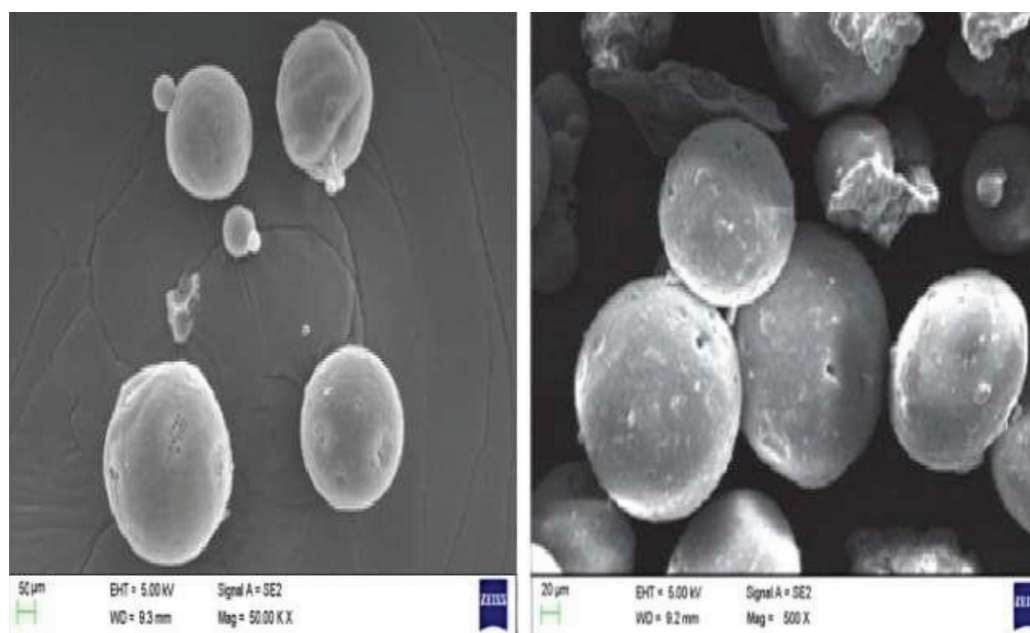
SEM images of optimised CT EPO microcapsules (F3)
